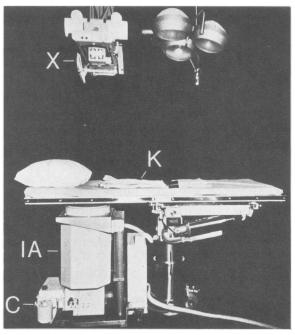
Equipment for fluoroscopic operative cholangiography. K: Kifa operating table with coordinate radiolucent table top. IA: Mobile image amplifier with beam splitter, television camera and 70 by 70 mm roll film camera (C). X: Overhead x-ray tube. Television monitor is not shown.
